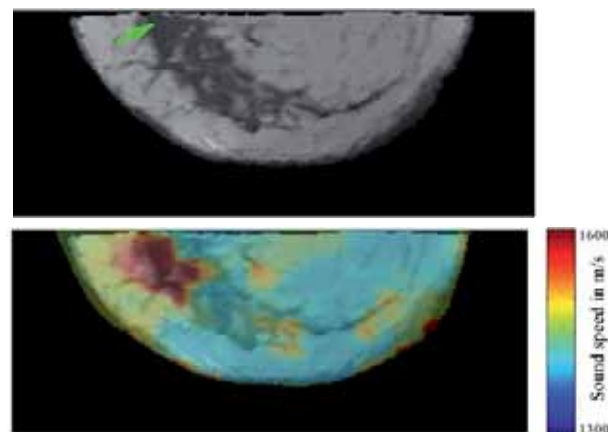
Transversal slice image of a patient with an inflammatory carcinoma (green marker) in the registered T1 MRI image (top) and fused image of the MRI with the USCT sound speed image (bottom). The sound speed information is color-coded and rendered semi-transparently on the MRI slice.
